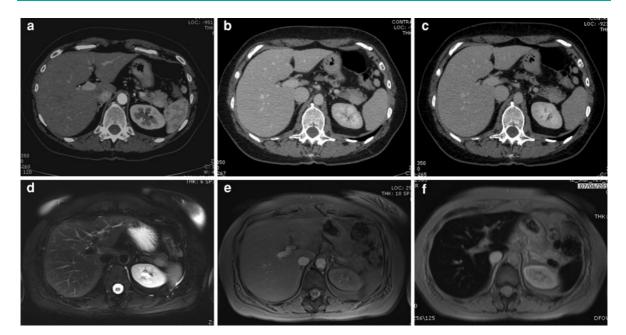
Intrapancreatic spleen. MDCT, arterial (a), venous (b) and distribution phase (c). During arterial phase (a) a hypervascular lesion in the tail of the pancreas can be appreciated, which shows the same contrast enhancement behaviour of the spleen in the different phases. (d) MRI, T2w
